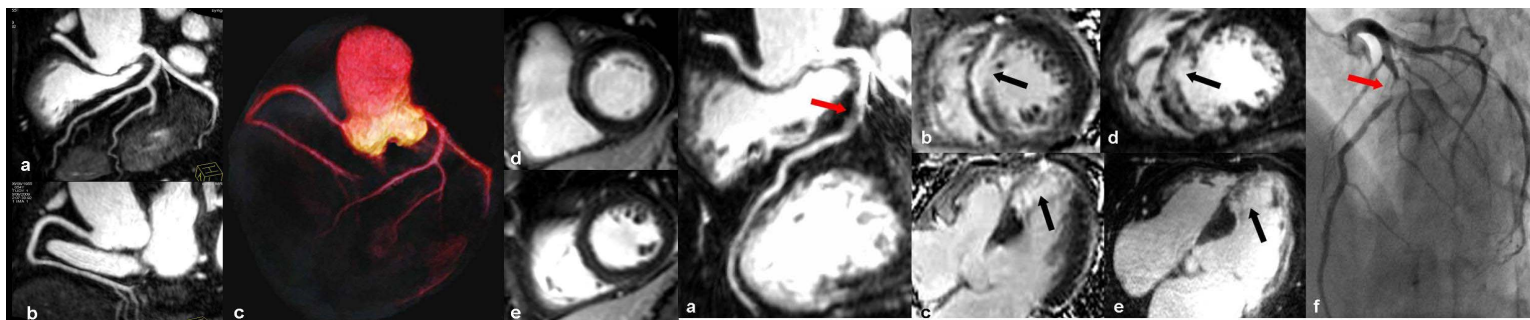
3T whole-heart coronary MR images of a 54 year-old patient acquired with 32-channel cardiac coils. Reformatted whole-heart coronary artery images (a,b) and viability images (d,e) demonstrate normal vessel and myocardium. Long segments of all major coronary arteries and normal myocardium can be clearly visualized on VR image (c)
